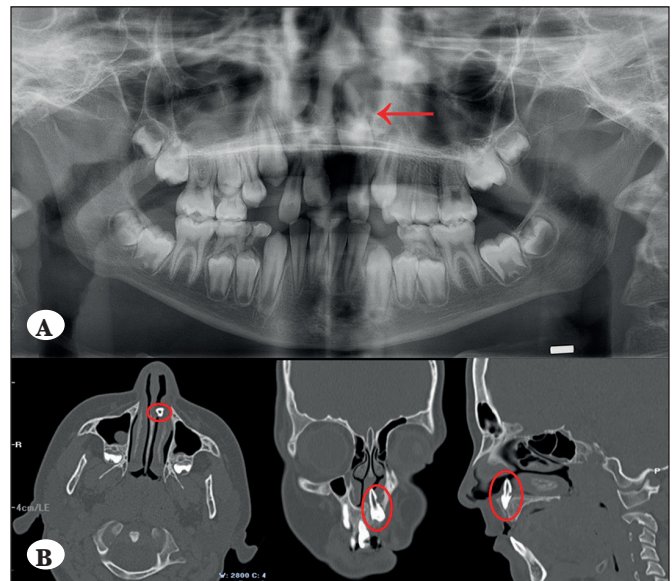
A) Panoramic radiograph of the patient at initial presentation. A maxillary left central incisor with root resorption is observed inside the left nasal cavity, B) Axial, coronal, and sagittal sections of the computed tomography scan confirms the complete intrusion of the maxillary left central incisor into the left nasal cavity. Red markers show the position of the intruded tooth.
